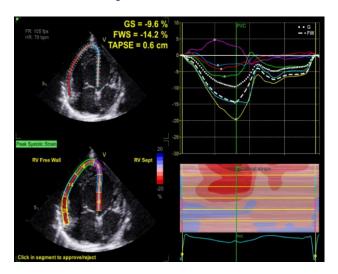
Four chambers echocardiographic view showing TAPSE for right ventricles which is severely depressed RV function.
